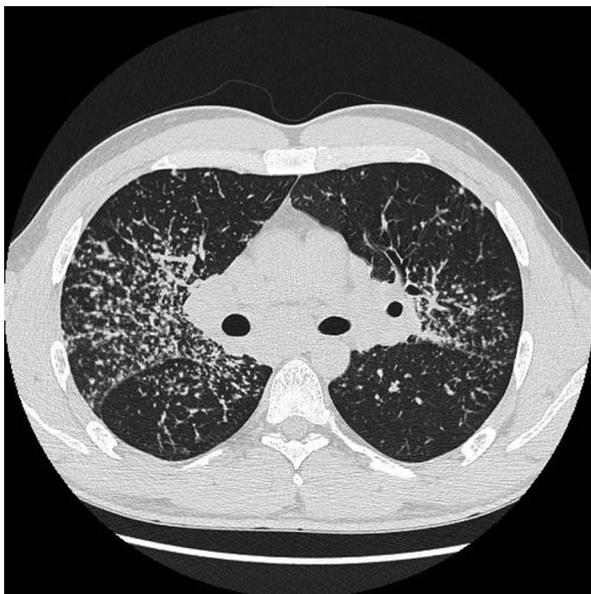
Chest high resolution computed tomography of the patient with stage II sarcoidosis. Enlarged hilar and subcarinal lymph nodes, disseminated high density nodules in both middle lung areas, with peribronchovascular and subpleural distribution
